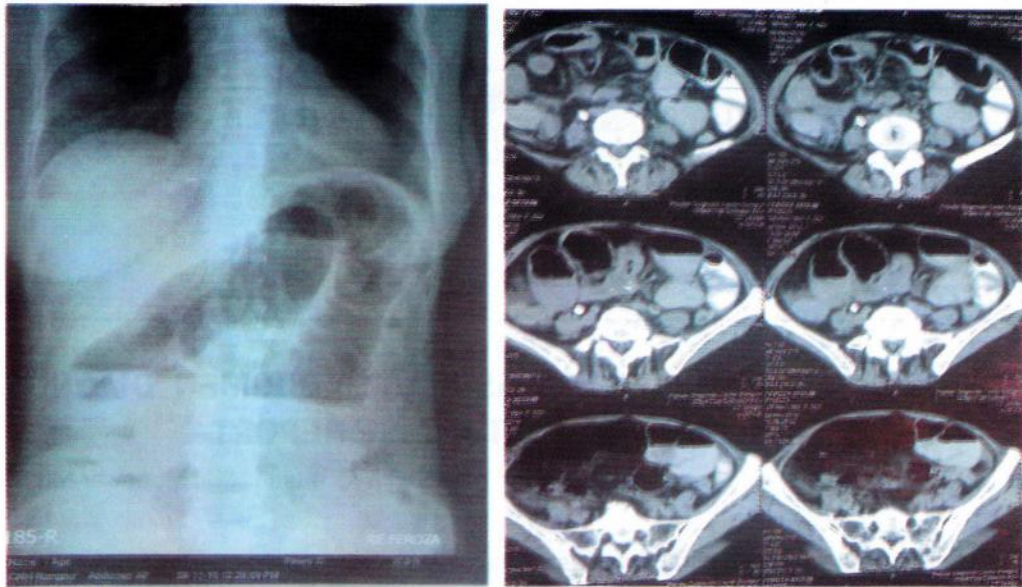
plain x-ray and CT scan of Abdomen shows feature of small intestinal obstruction.
